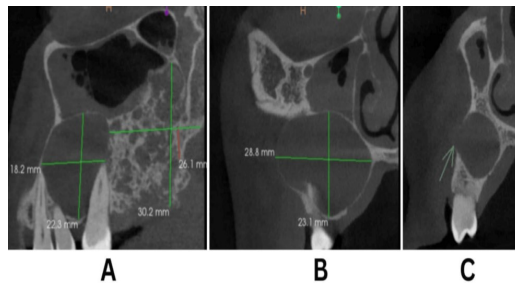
CBCT images showing Saggital and Coronal sections of the lesion.
